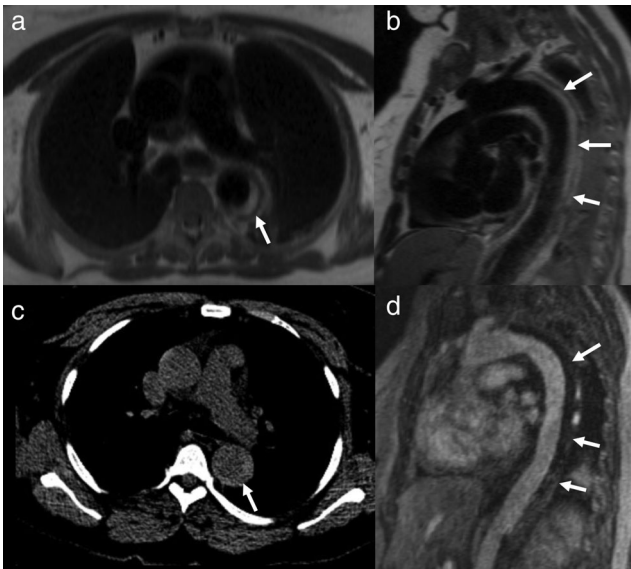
Black-blood MRI of Type B aortic intramural hematoma in a 65-year-old woman presenting with chest pain. Transaxial and oblique sagittal black-blood single-shot FSE MR images (a,b, respectively) demonstrates a smooth crescent of high signal intensity within the wall of the descending thoracic aorta (arrows), extending from just distal to the takeoff of the left subclavian artery inferiorly to at least the diaphragmatic hiatus, consistent with a Type B intramural hematoma. A high-attenuation crescent is seen at this location on a contemporaneous transaxial noncontrast CT image (c, arrow). Notably, the intramural hematoma is more difficult to appreciate on the contrast-enhanced oblique sagittal MRA image (d, arrows). The patient was managed with aggressive blood pressure control, and her intramural hematoma progressively decreased in size and eventually resolved over the next 4 years.
